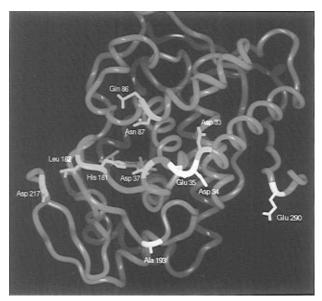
Surface of cytochrome *c* peroxidase showing two possible cytochrome *c* binding sites. The residues in yellow represent the cytochrome *c* binding site originally determined by visual docking of cytochrome *c* peroxidase and cytochrome *c* using computer graphic techniques (Poulos & Kraut, 1980; Poulos & Finzel, 1984). This binding site is referred to as the Poulos/Finzel/Kraut binding site in the text. The residues in white define the cytochrome *c* binding site, determined by X-ray analysis of two cytochrome *c*/CcP complexes (Pelletier & Kraut, 1992). The binding site in white is referred to as the Pelletier/Kraut binding site in the text.
